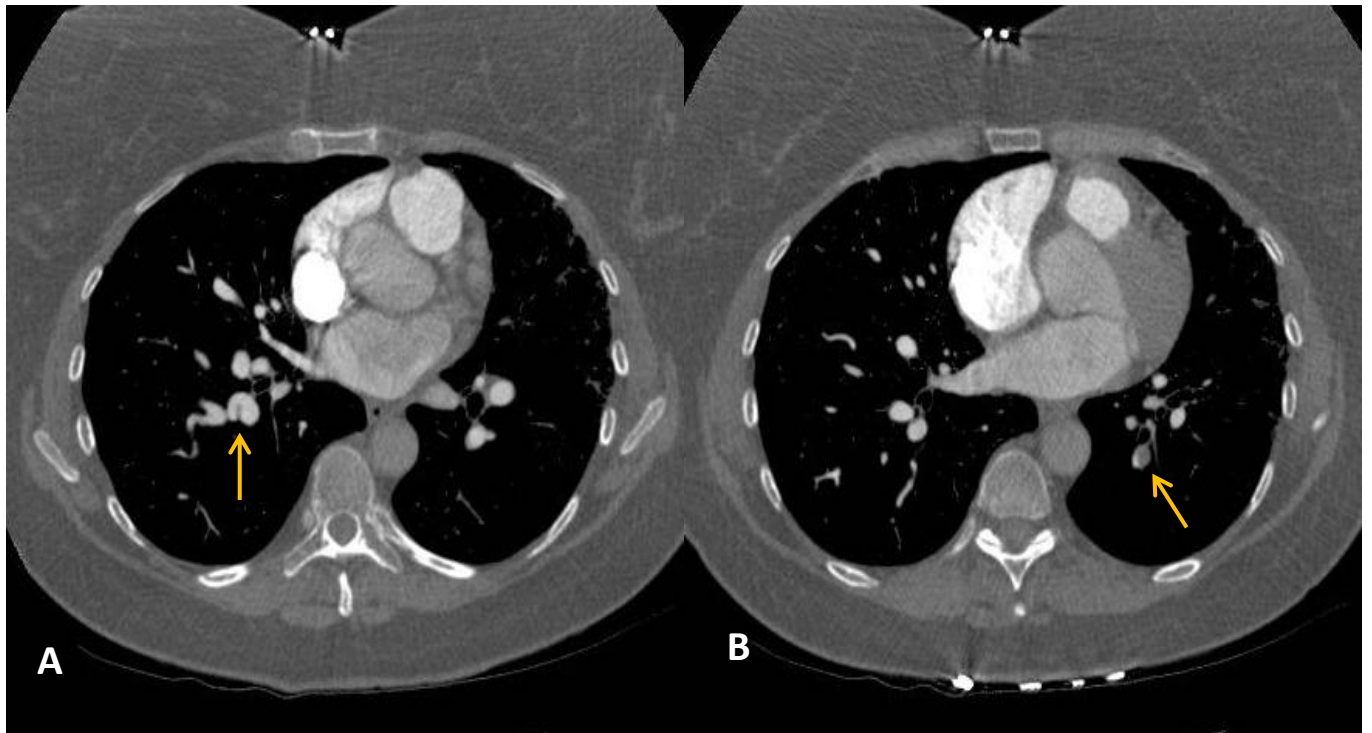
Axial CT- webs in the right lower lobar artery (A) and occlusion of the left lower branch in a patient with CTEPH (B)
